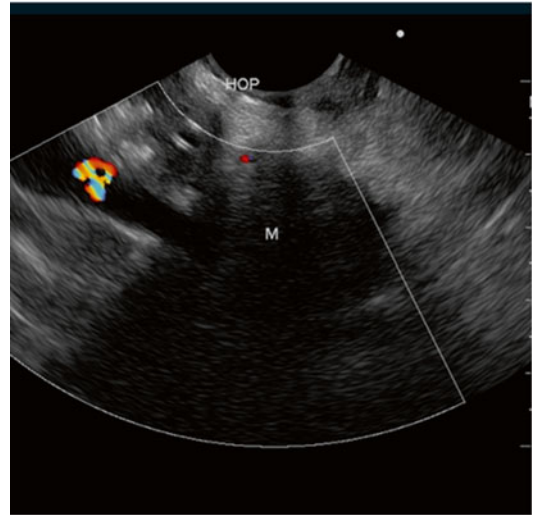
A hypoechoic mass at the head of the pancreas with invasion into the main portal vein is demonstrated. A plastic biliary stent was endosonographically demonstrated by the couple of linear echogenic lines in the left upper corner of the figure
